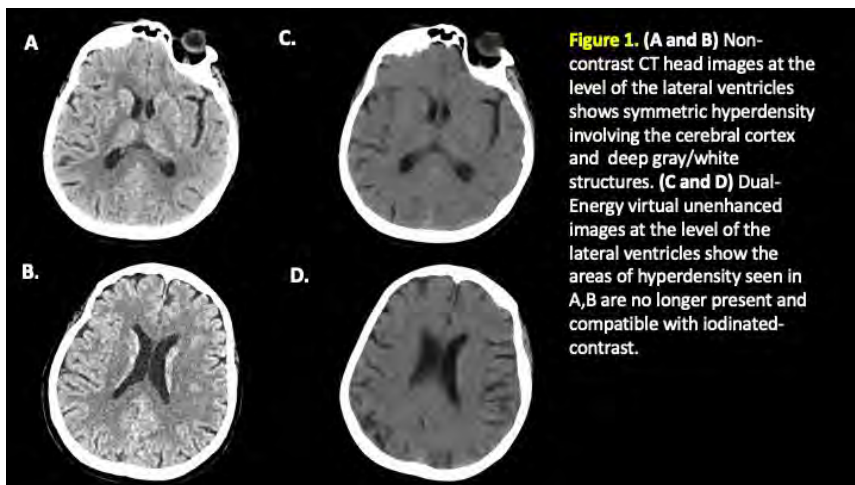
(A and B) Non-contrast CT head images at the level of the lateral ventricles shows symmetric hyperdensity involving the cerebral cortex and deep gray/white structures. (C and D) Dual-Energy virtual unenhanced images at the level of the lateral ventricles show the areas of hyperdensity seen in A,B are no longer present and compatible with iodinated-contrast.
